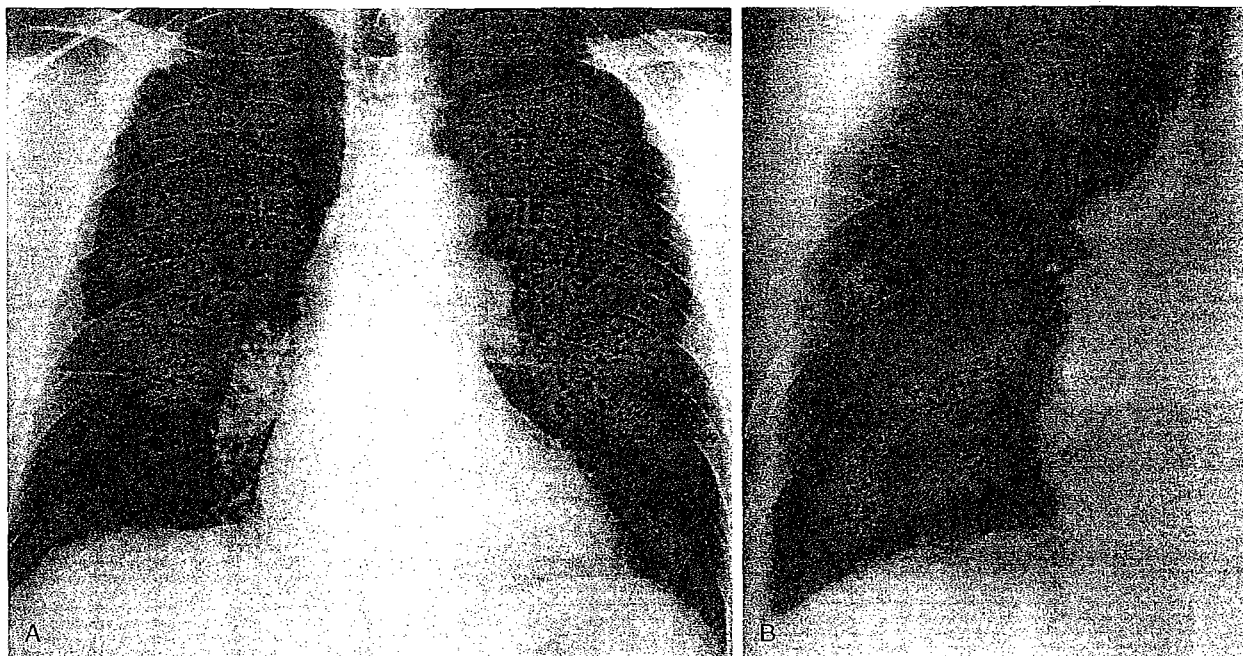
Carborundum Lung. A posteroanterior chest radiograph (A) demonstrates bilateral hilar lymphadenopathy as well as small nodular and irregular linear opacities involving mainly the lower lung zones. A magnified view of the right lower lung (B) better demonstrates the fine reticulonodular pattern and interlobular septal thickening. The patient had been exposed to carborundum for 33 years in a factory manufacturing abrasives. (Courtesy of Dr. Gaston Ostiguy, Maisonneuve-Rosemont Hospital, Montreal.)
